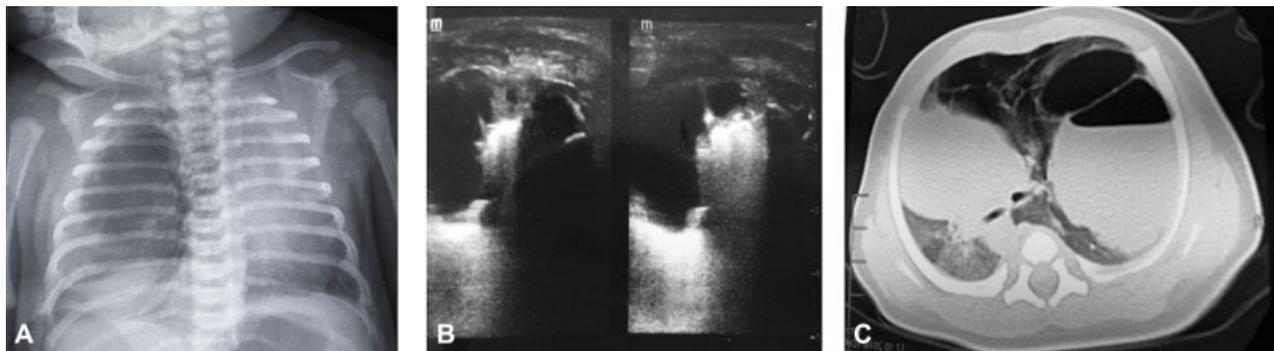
(A) CXR_DOL 1: upper-middle pneumothorax with mediastinal shift to the left. (B) LUS-DOL 1: macrocystic lesions (≥ 5 mm according to Adzick classification) of the right middle and upper lobes. (C) CT scan-DOL 1: CPAM type I. CPAM, congenital pulmonary airway malformation; CT, computed tomography; CXR, chest X-ray; DOL, day of life; LUS, lung ultrasound.
